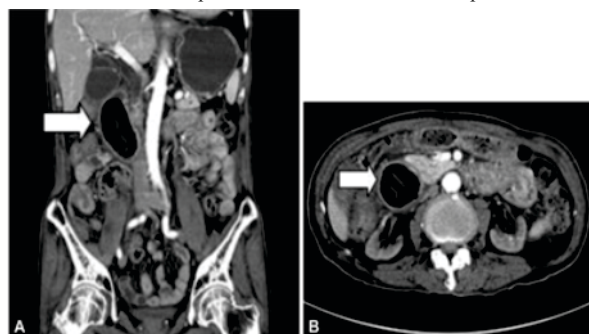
(A) Abdominal computed tomography scan shows a duodenal mass considered to be a bezoar (white arrow). (B) Axial view (white arrow).
